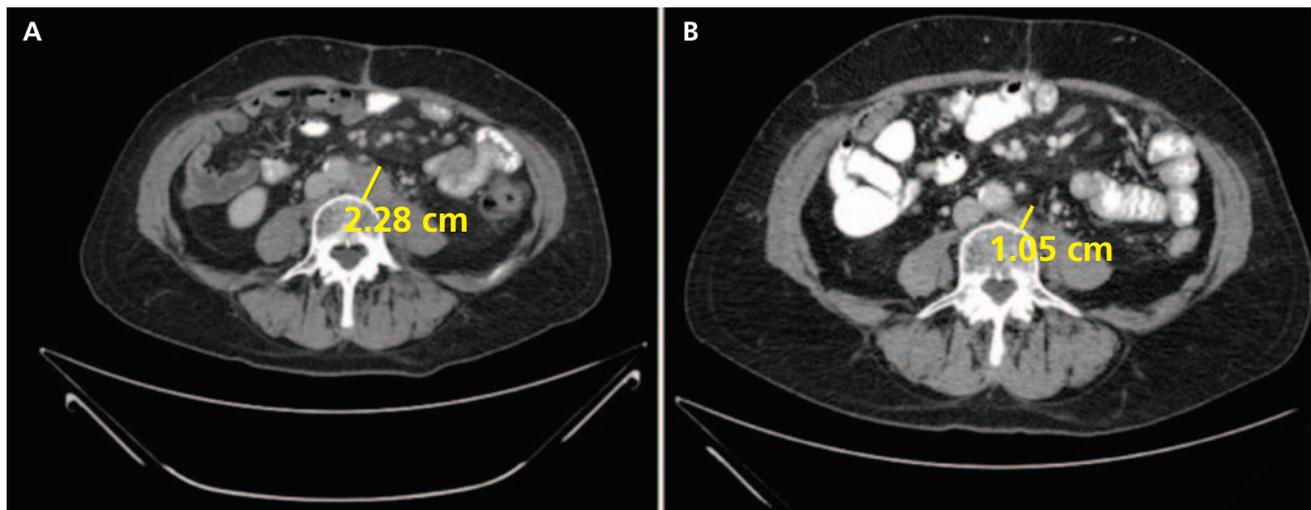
Representative CT images showing para-aortic adenopathy before (A) and after (B) treatment with 3 cycles of brentuximab vedotin.
